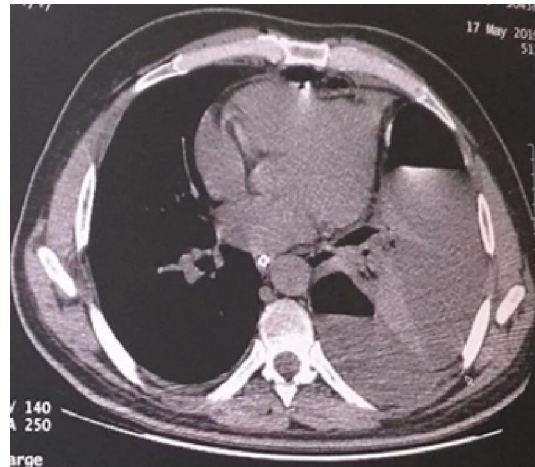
CT chest was done revealing collection and emphysema of the left lung
